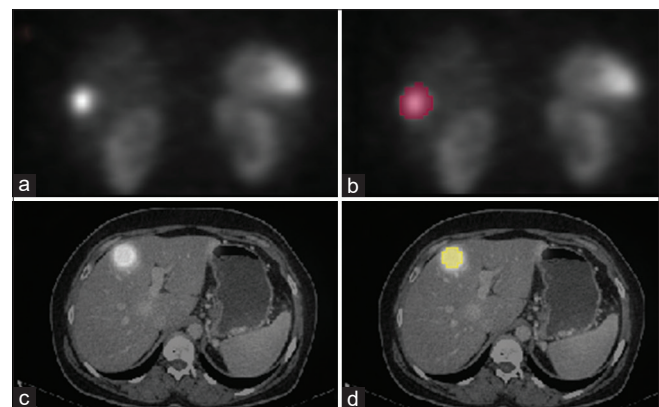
(a) Single-photon emission computed tomography (SPECT) image of a patient with neuroendocrine tumors (NETs). (b) Segmentation of the region of interest in the SPECT image. (c) Single-photon emission computed tomography–computed tomography (SPECT-CT) image of a patient with NETs. (d) Segmentation of the region of interest in the SPECT-CT image
